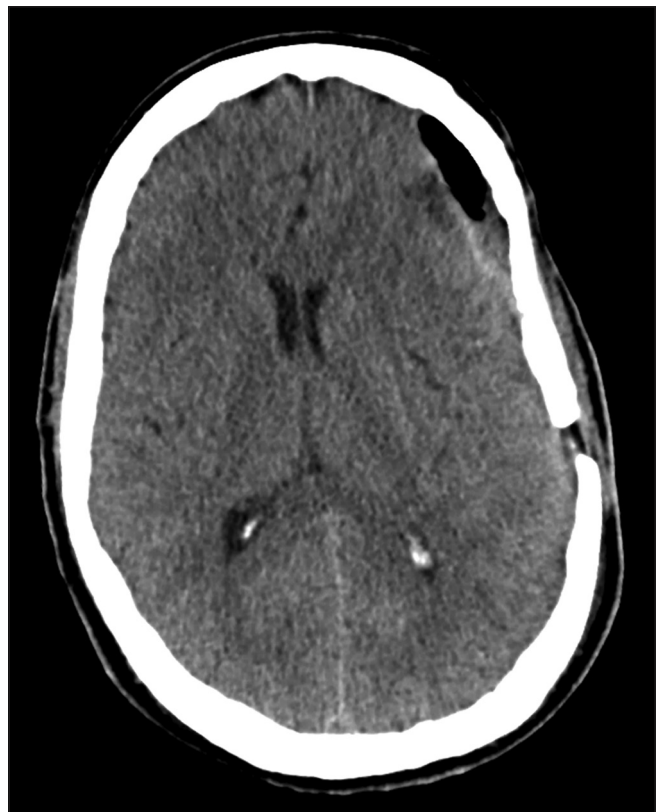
Control computed tomography scan showed small fluid accumulation and pneumocephalus
